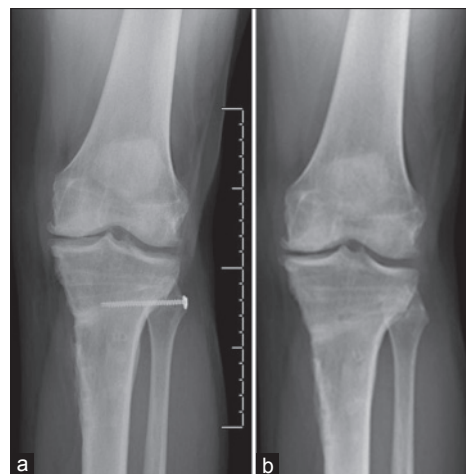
The radiograph of knee joint anteroposterior projection (a) showing arthrodesis with a compression screw 3 months after the operation (b) 3 months after the screw removal
